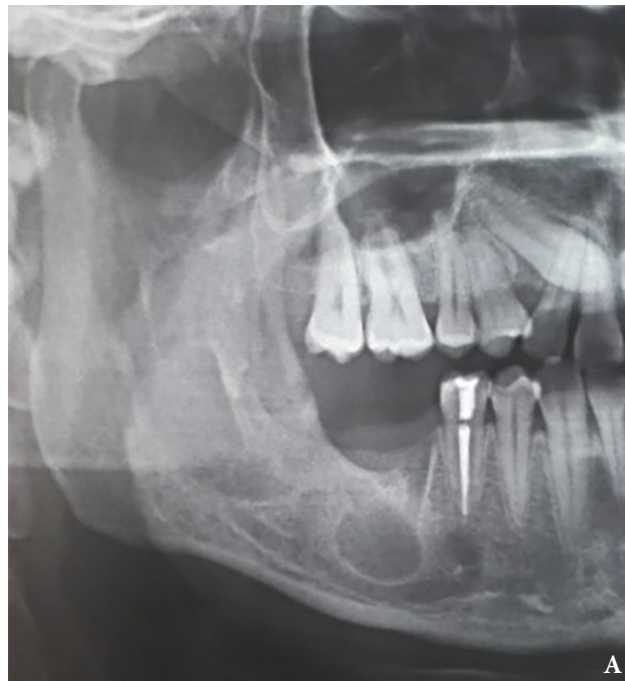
Case 1: Radiography. A: 6 months post-op. B: 1 year post-op. C: 2 years post-op.
